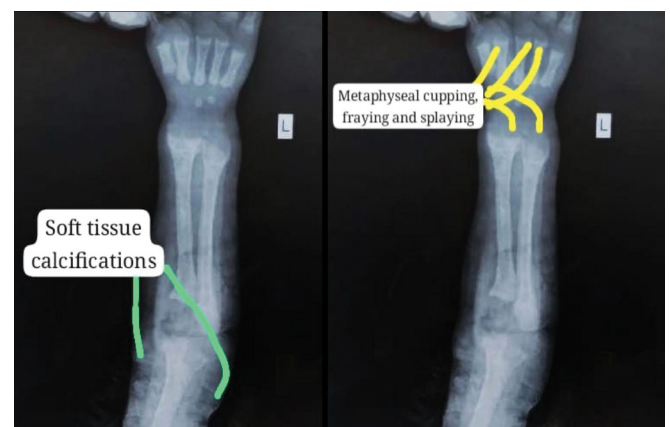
X-ray of the patient's left arm displaying soft tissue calcifications attributed to excessive vitamin D intake on the left, alongside metaphyseal cupping, fraying, and splaying on the right side.
